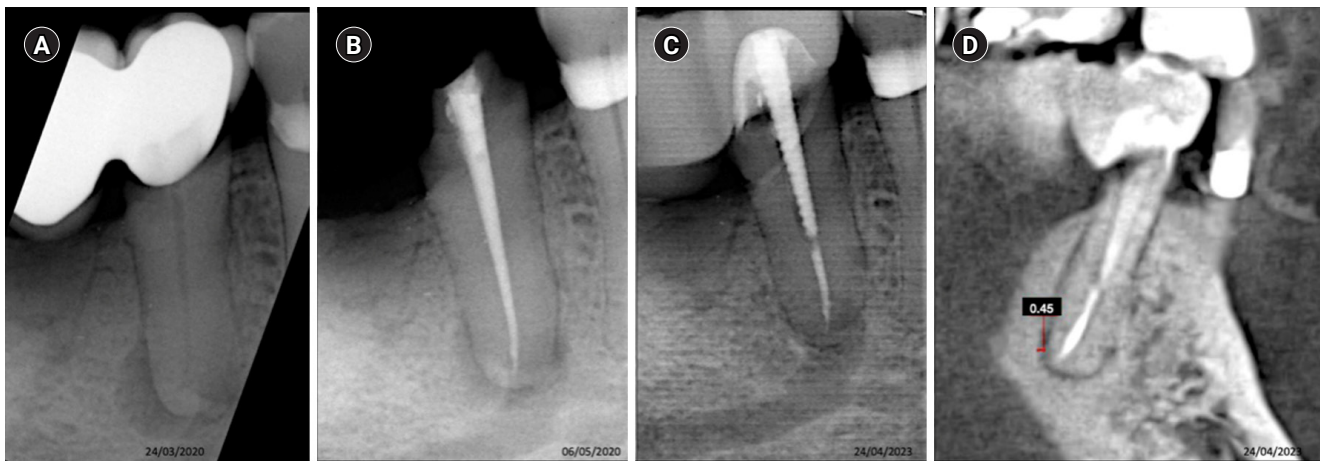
Tooth 36 with a diagnosis of Pulp necrosis with acute periapical abscess. (A) Diagnostic X-ray. (B) Immediate after obturation. (C) Tomographic control after 24 months. showing the apical lesion in the same manner as in the initial X-ray, considered a failure.
